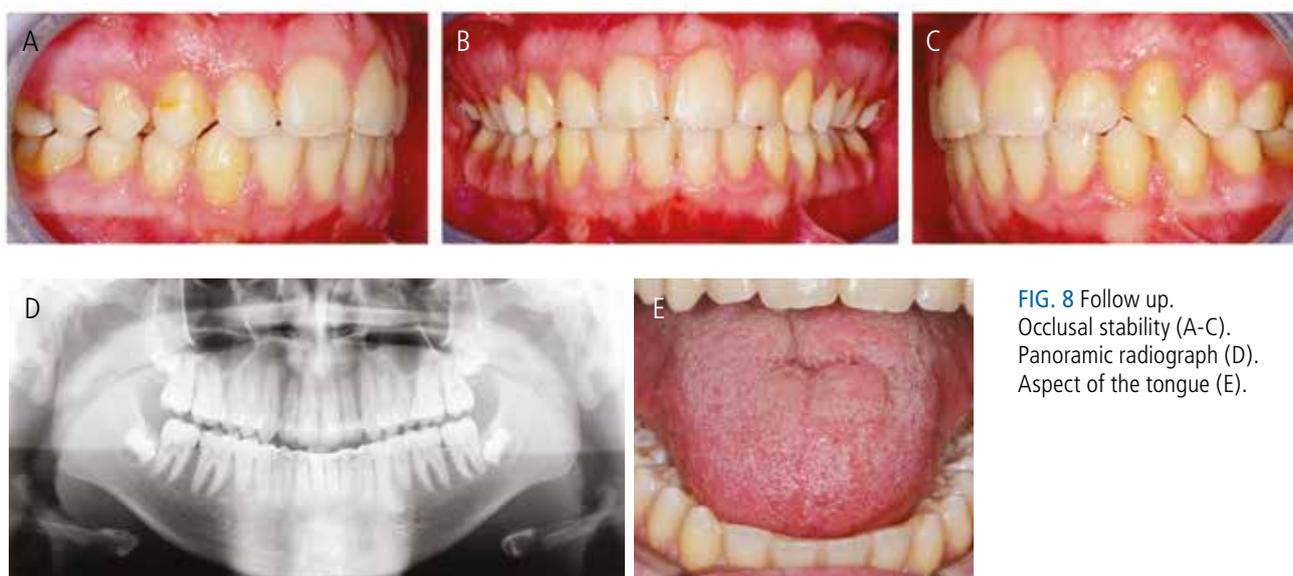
Follow up. Occlusal stability (A-C). Panoramic radiograph (D). Aspect of the tongue (E).
